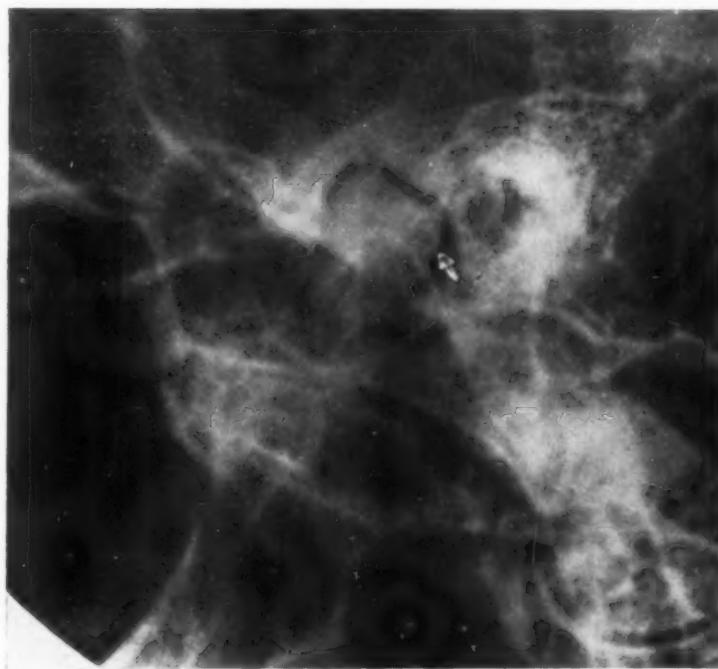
X-ray film of right condyle. Note enlargement and arthritic change.
